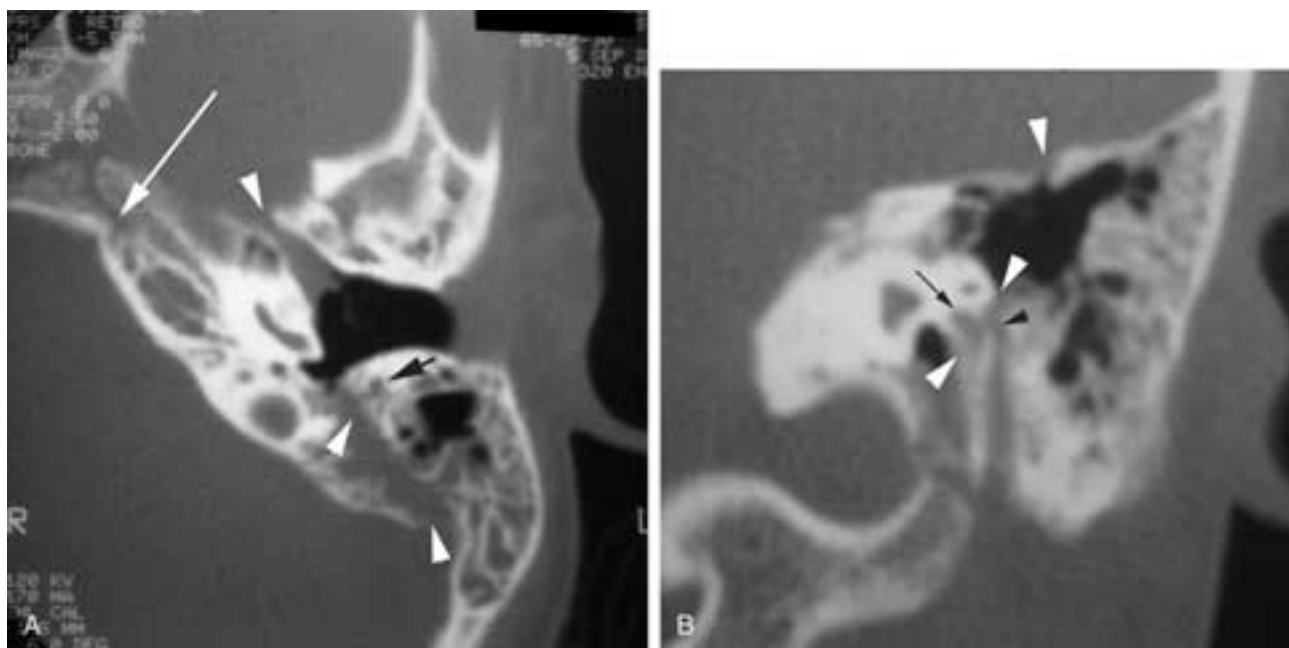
Fracture dislocation of the temporal bone apex (floating petrous bone). CT. This child had a compression from laterally and presents with facial paralysis and sixth nerve palsy. A, Axial scan shows the fracture (arrowheads) crossing from the posterior plate of the mastoid anteriorly through the middle ear, exiting by the anterior genu of the facial nerve. The medial portion of the temporal bone (including the labyrinth) is a single movable fragment. This part of the bone has rotated slightly, impacting the tip against the clivus. This pinches into Dorrello's canal (white arrow), explaining the sixth nerve palsy. The fracture separates the mastoid segment (black arrow) of the facial nerve from the tympanic segment, explaining the facial paralysis. B, Coronal image shows the fracture line (white arrowheads) passing through the tegmen, then crossing the facial nerve into the middle ear. Note that the fracture separates the facial canal mastoid section (black arrowhead) from the tympanic section (black arrow).
